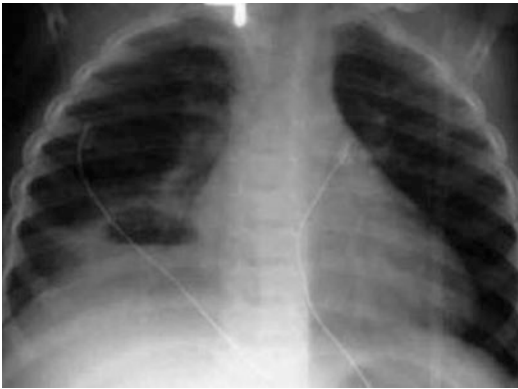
Pulmonary abscess. Chest X-ray in 14-month-old infant evolving with sepsis and pulmonary abscess in the right middle lobe
